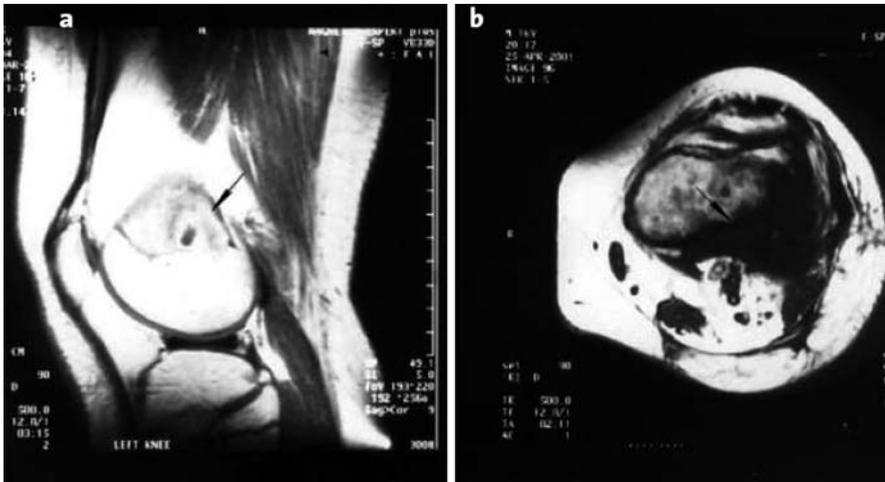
Magnetic resonance imaging (MRI) of the distal part of *left* femur and the knee in a patient with CGD and osteomyelitis due to *A. niduland*. *Arrows* indicate the sites of the lesions. (a) At the beginning of the infection (day 3 of hospitalization), MRI shows an osteomyelitis of the distal metaphysis of the femur without participation of the surrounding soft tissues. (b) On day 60 of hospitalization, MRI shows increased bone destruction compared to the previous examination [7]
